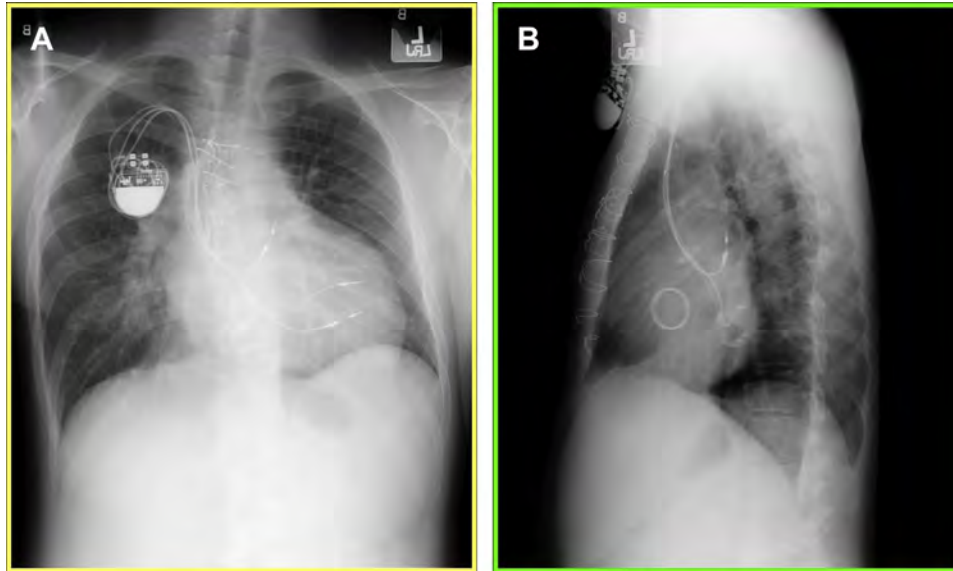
(A) Anteroposterior and (B) lateral chest radiographs demonstrate the posterior positioning of atrial and ventricular pacemaker leads in the systemic venous baffle in an adult after a Senning operation.
